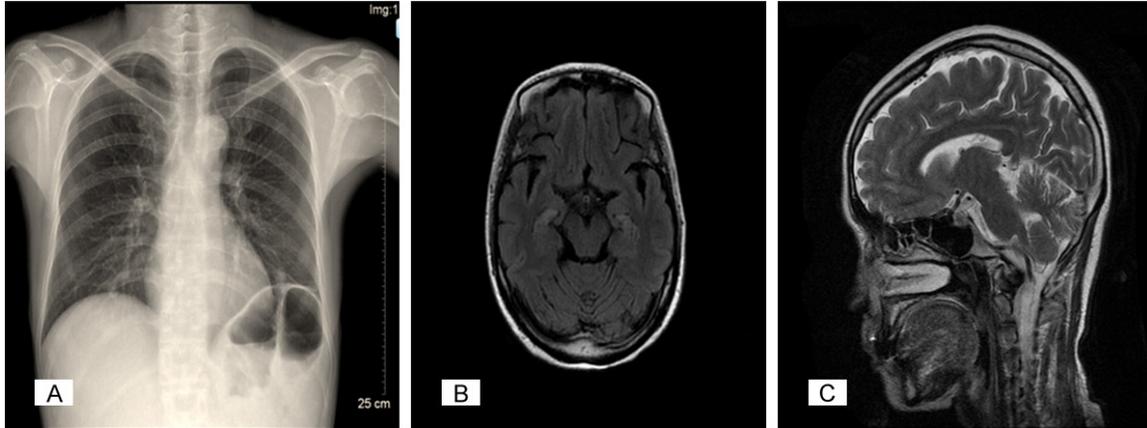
A. A posteroanterior chest radiograph showed infiltration of the left lower lung field and left diaphragmatic lift. B, C. Brain magnetic resonance imaging showed mild encephalatrophy and degeneration in bilateral hippocampi.
